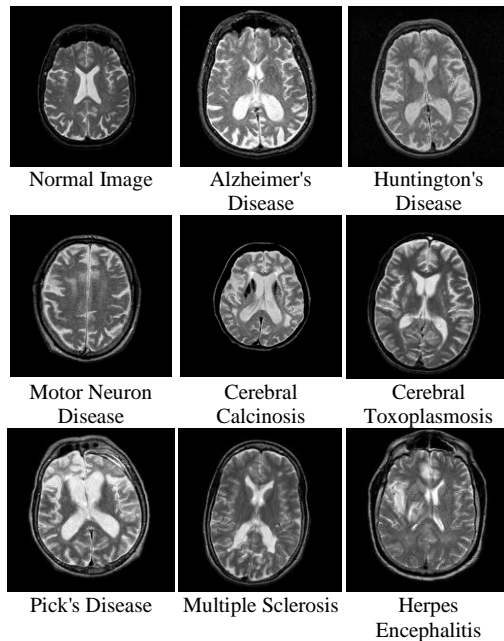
Sample brain MRI images from the whole brain atlas
